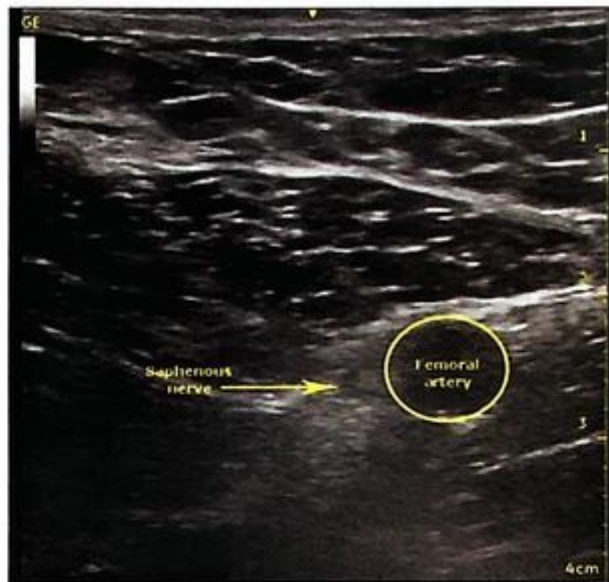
Ultrasound image of the adductor canal.
